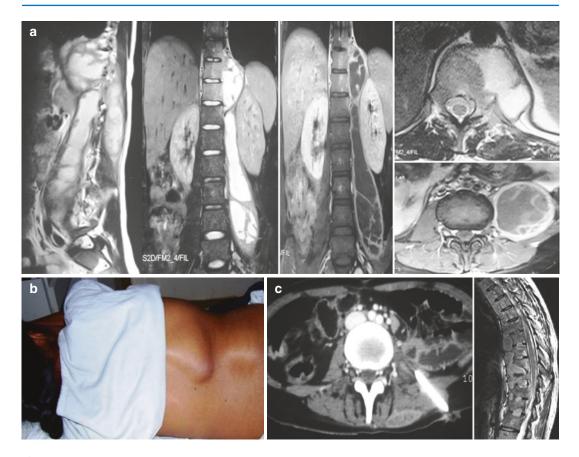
(a) Parasagittal coronal and axial MRIs showing the extensive abscess complicating the thoracolumbar Pott's spine. The characteristic of the pus is in revealed in different sequences of MRI (T1/T2/T1 contrast). (b) The
